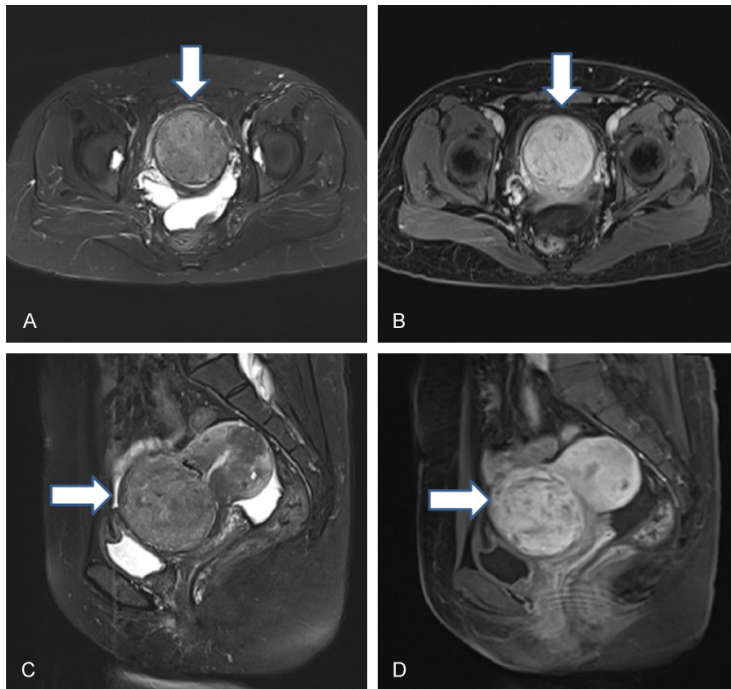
MR images of a 47 year old patient with leiomyoma of the anterior cervical lip (A). T2 fat suppression sequence (axial) showed slightly high signal mass in the middle of anterior lip of cervix with uneven signal (white arrow). (B) T1WI enhanced sequence (axial) showed that the cervical mass with significantly heterogeneous enhancement. (C) T2 fat suppression sequence (sagittal) showed a slightly hyper-intense mass in the anterior lip of the cervix with compression and displacement of surrounding structures (white arrow). (D) T1WI enhanced sequence (sagittal) showed obvious heterogeneous enhancement of cervical mass (white arrow).
